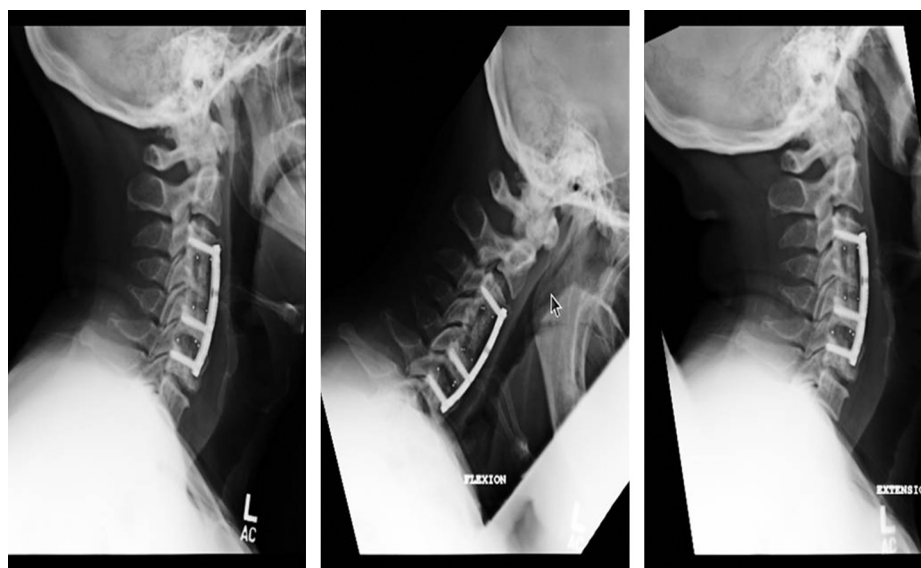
Postoperative lateral (left) neutral, (middle) flexion, and (right) extension radiographs at 8 months follow-up showing solid fusion in a patient who underwent C4 corpectomy, C5/6 discectomy, reconstruction with polyetheretherketone cages and C3–C6 plating.
